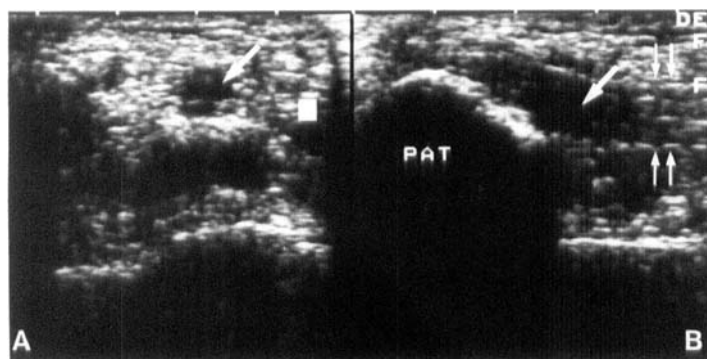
Ultrasonography (7.5 Mhz probe) showing a partial rupture (arrows) of the quadriceps tendon. Transverse (A) and longitudinal (B) projections. PAT patella. Quadriceps tendon (small arrows).
